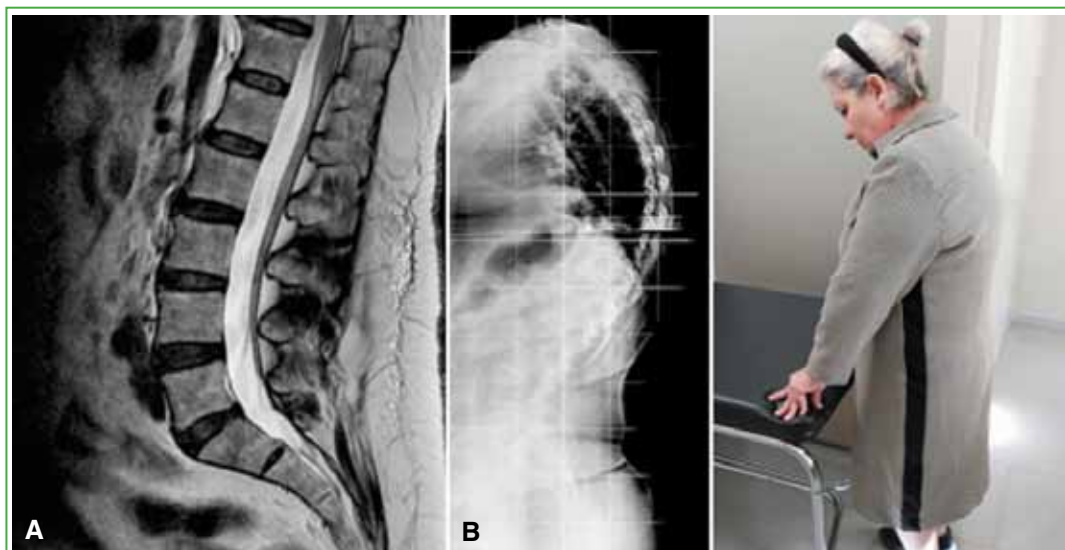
Figure 4 patient. A. MRI showing a healthy spine with no structural condition. B. Radiograph showing marked kyphosis and lordosis while standing due to muscle weakness. Full-body muscle MRI was performed. The atrophy was restricted to the lumbar erector muscles
